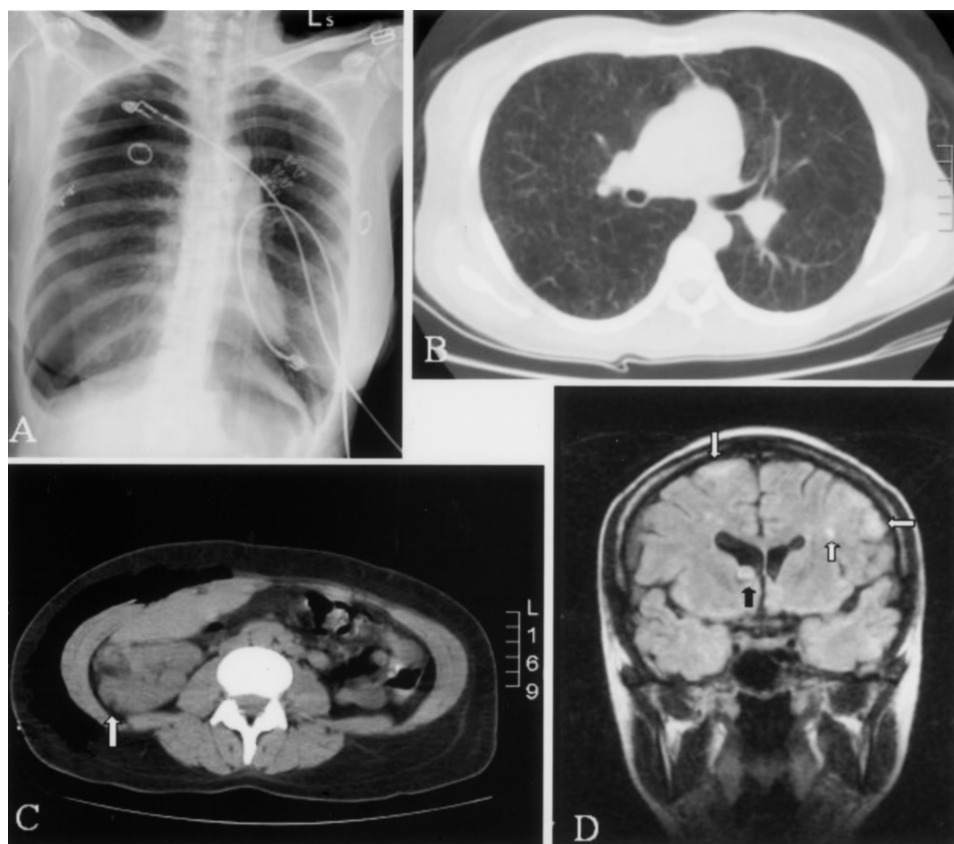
Radiologic images. A. CXR. Pneumothorax in the right side, and increased lung volume with a flap of the diaphragm in the left side of the lung. B. HRCT. Multiple cystic lesions in the bilateral lungs. C. CT scan of abdomen without enhancement. Right renal angiomyolipoma (arrow): huge mass with fat and soft tissue densities. D. MRI of the brain. Subependymal nodules or giant cell astrocytomas in the ventricle (black arrow), and tubers (white arrows) in the cortex of the brain.
